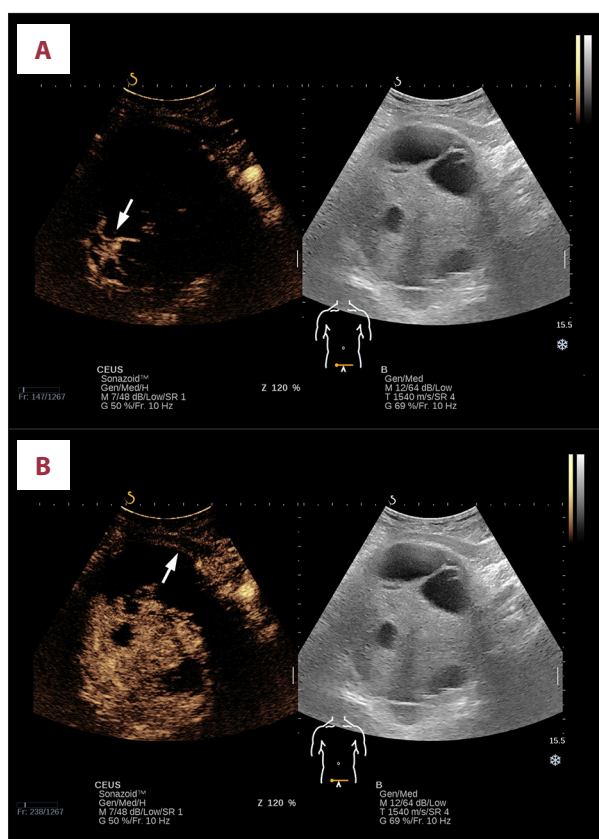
Contrast-enhanced ultrasound of pelvic schwannoma. (A) Early phase (11 s) showing tree-like enhancement of the solid component and capsule from periphery to center (arrows). (B) Mid-phase (24 s) showing progressive enhancement of the solid component with scattered non-enhancing areas; capsule remains intact (arrows); cystic component remains non-enhancing. (C) Late phase (38 s) showing delayed washout of the solid component with uneven low enhancement.
